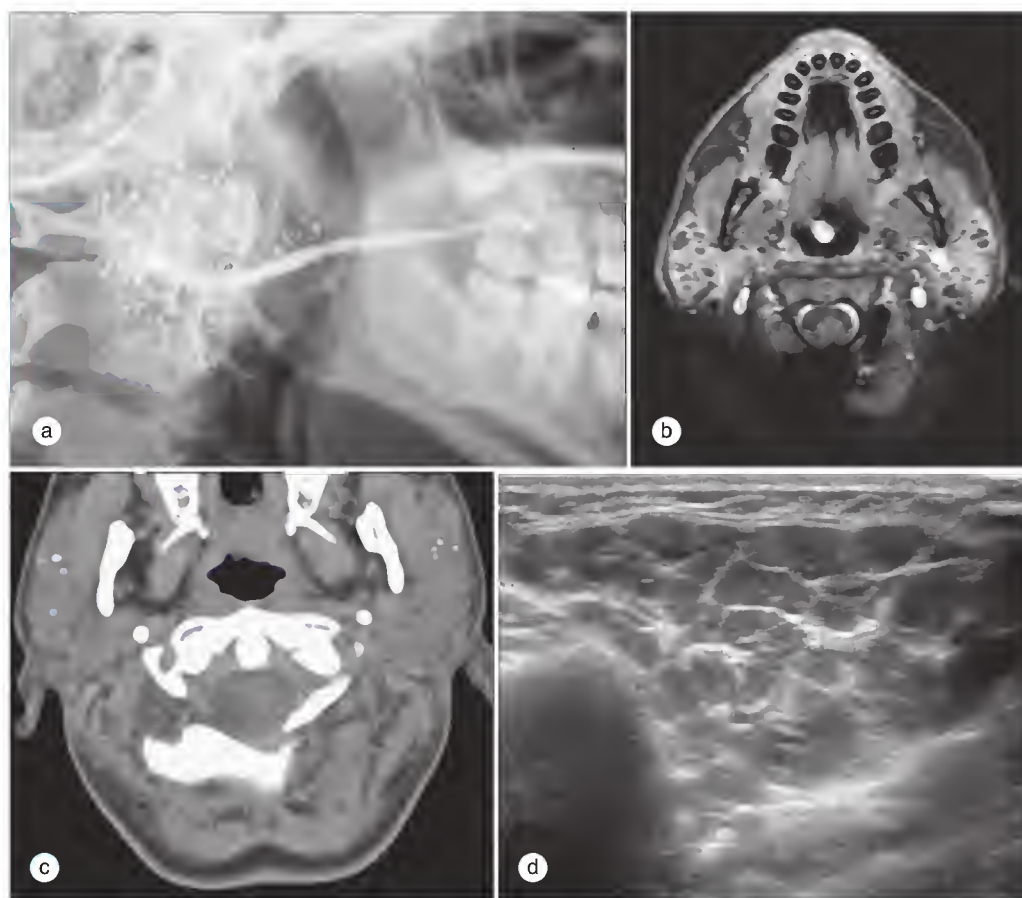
Imaging of the parotid glands in Sjögren syndrome. (a) Contrast-enhanced sialogram in a patient with Sjögren syndrome. The multiple small round opacities present at the termination of the smaller ducts (sialectasia) has led to the appearance of a branchless fruit-laden tree or "mulberry" pattern. (b) Magnetic resonance imaging. On this T1-weighted image, both hypointense cystic structures and hyperintense foci are evident in the parotid gland parenchyma. (c) Computed tomography. In this tomographic section, punctate areas of calcification are apparent in the parotid gland parenchyma. This image is from a study of the same patient as in panel b. (d) Ultrasonography. Note the parenchymal inhomogeneity with numerous rounded hypoechoic areas delineated by hyperechoic linear reflectors.
